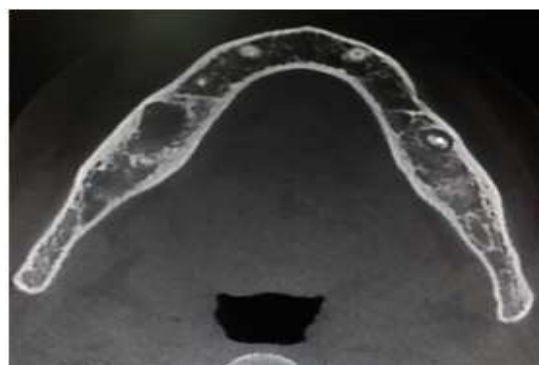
CBCT scan of periapical radiolucency in a 47-year old woman (right first molar of mandible)
